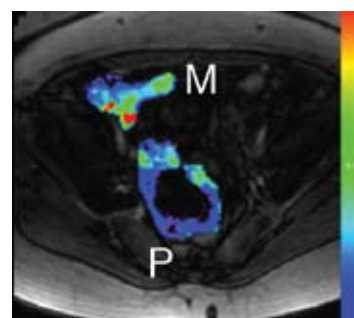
Dynamic contrast enhanced MRI showing  $K_{trans}$  maps from primary (P) ovarian cancer and peritoneal metastasis (M). There is differential perfusion within tumour masses with highest (red) values seen in the metastatic disease.
